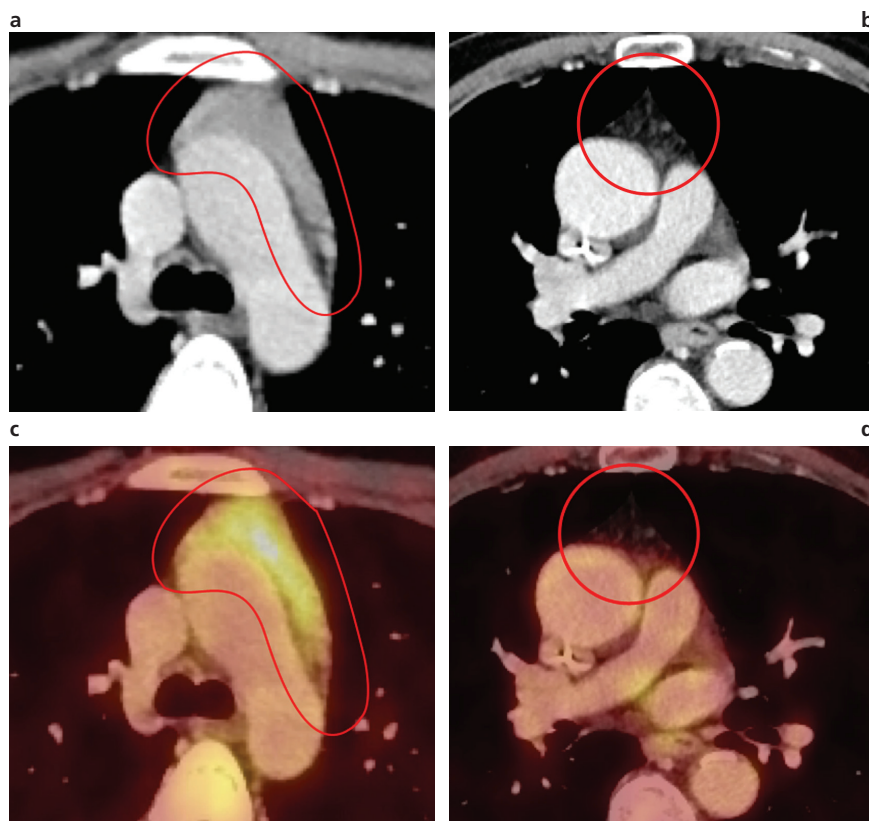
Physiological thymus: age-related changes. Axial intravenous (IV) contrast-enhanced CT (A and B) and PET-CT fusion imaging (C and D). Twenty-year old and sixty-five year-old patients (left and right, respectively) with no previous history of chemotherapy. The 20-year-old patient has a quadrilateral thymus with mild 18-FDG uptake, while the 65-year-old patient has a triangular thymus with no significant 18-FDG uptake, demonstrating fatty degeneration typical of the involutinal process associated with aging.
